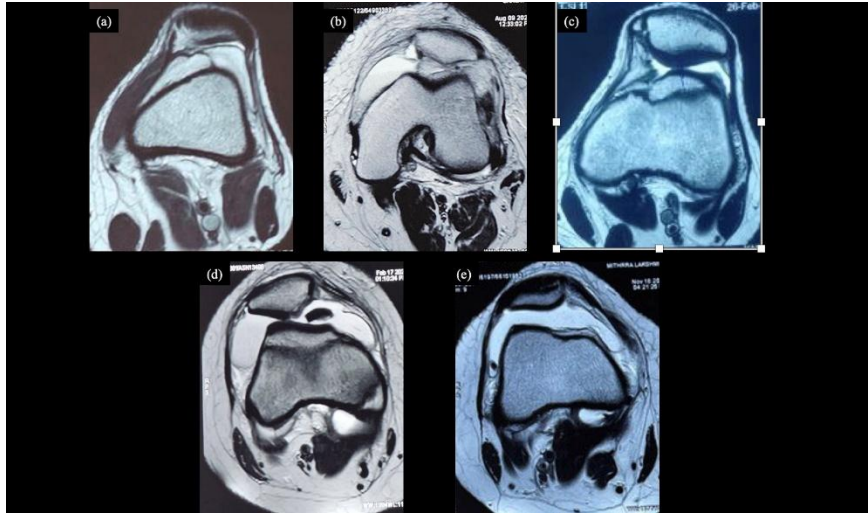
Axial MRI images showing MPFL avulsion injuries.
